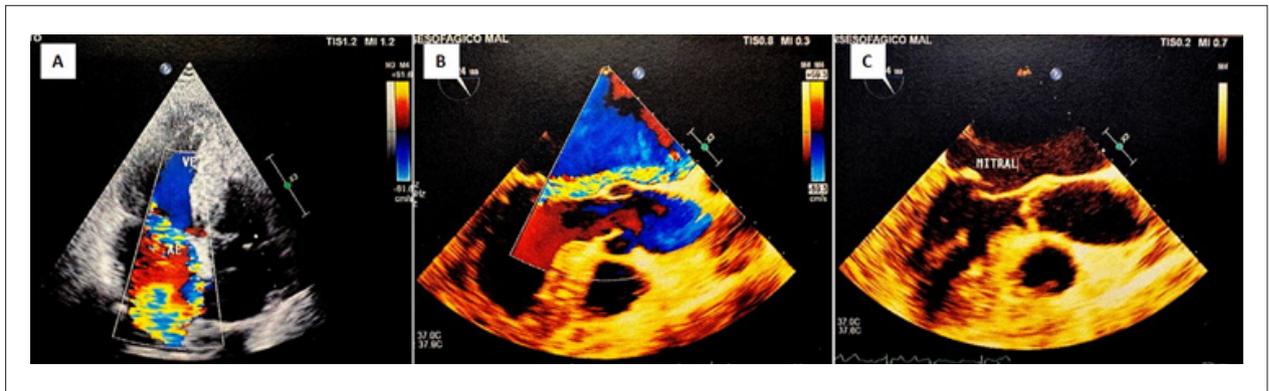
Preoperative transesophageal echocardiography. (A) and (B): Significant eccentric MR. (C): Mitral valve prolapse with myxomatous degeneration and partial rupture of pretendinous cords (flail) of the posterior leaflet (P2 segment).
